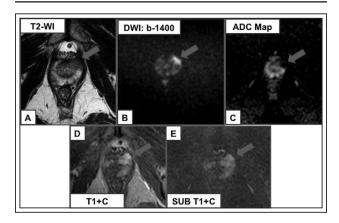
Axial T2WI image (A) demonstrates a hypointense lesion in the anterior peripheral zone of left mid gland (arrow), DWI b-value 1400 (B) demonstrates marked hyperintense signal corresponding to the findings on T2WI, ADC map (C) demonstrates marked hypointense signal in keeping with diffusion restriction, dynamic contrast-enhanced image (D) demonstrates avid early arterial hyperenhancement, subtracted image of the DCE (E) demonstrates avid arterial hyperenhancement. This is a PIRADS 4 lesion given its size and findings on T2WI and DWI. The findings on the DCE sequence added no value in this patient.
